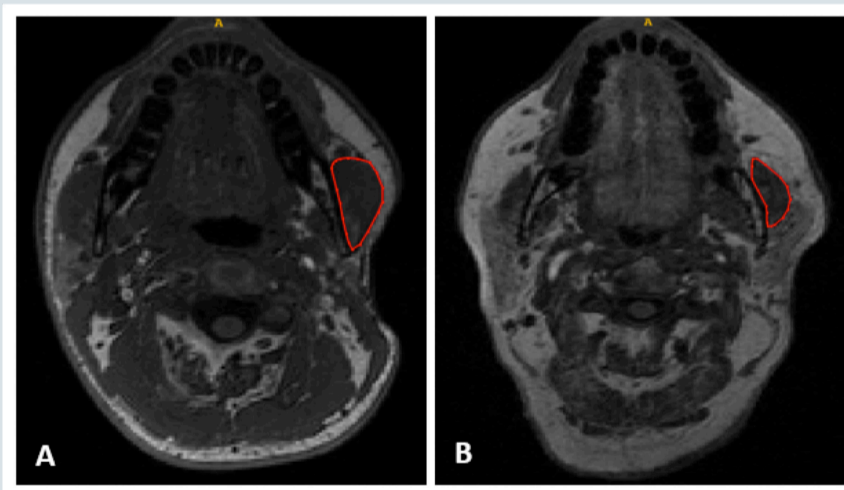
MRI scans at the same level for a control participant (A) and DM1-affected participant (B). Generalised muscle atrophy with extensive fatty infiltration is seen in the affected participant.
